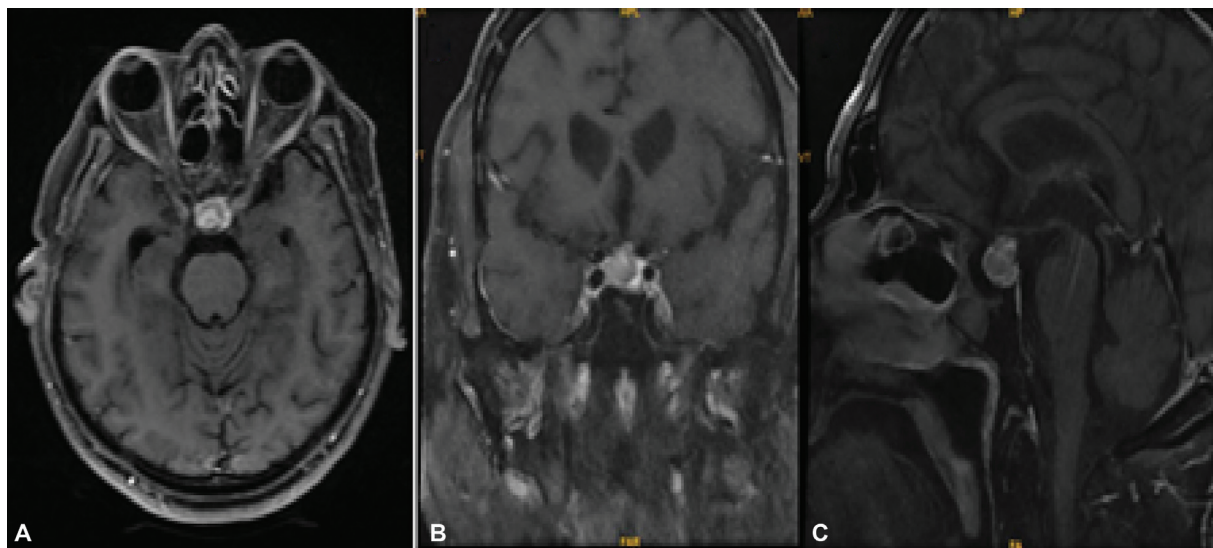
Magnetic resonance imaging (MRI) brain contrast in October 2018 residual pituitary adenoma with no other lesion noted.
